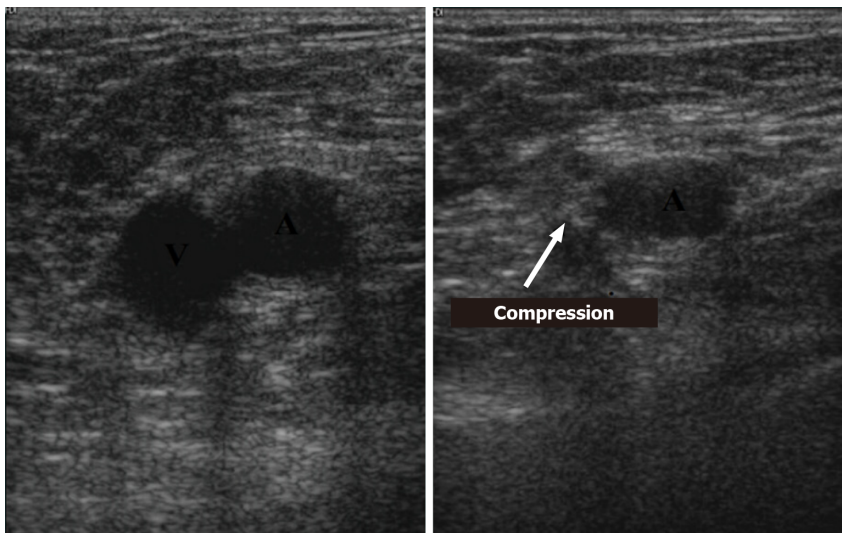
Compression ultrasound example.
